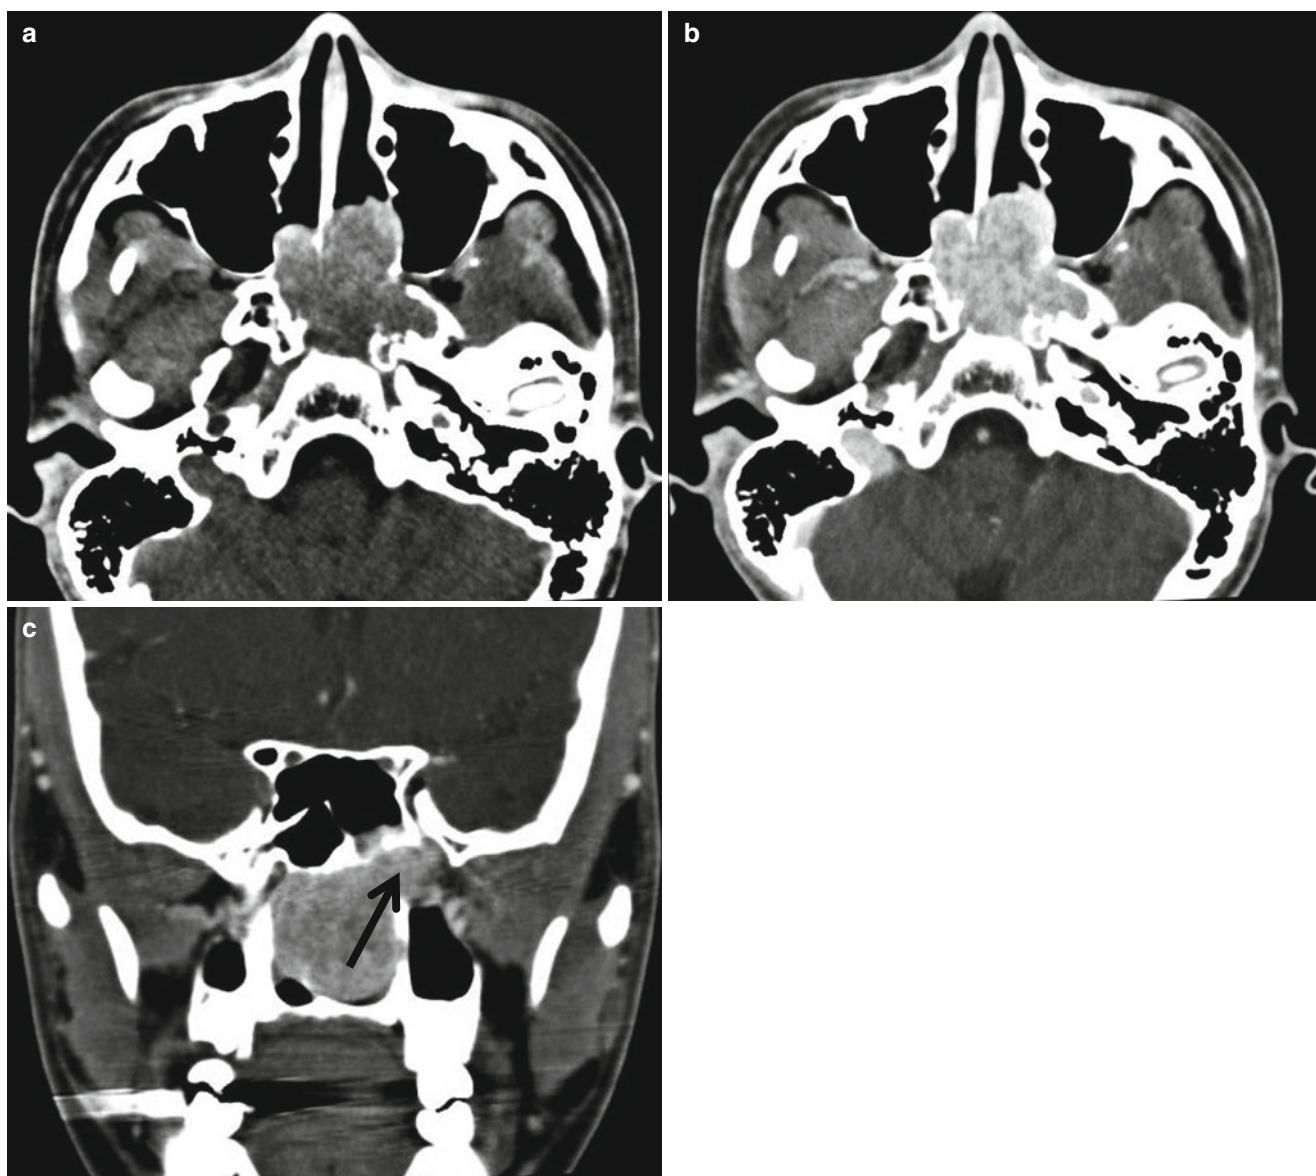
Nasopharyngeal angiofibroma in an 18-year-old boy. (a) Nonenhanced axial CT scan shows iso- to high-attenuated soft tissue tumor obstructing the nasopharynx. (b, c) Contrast-enhanced axial and coronal reformatted CT scans show an avidly enhancing tumor
